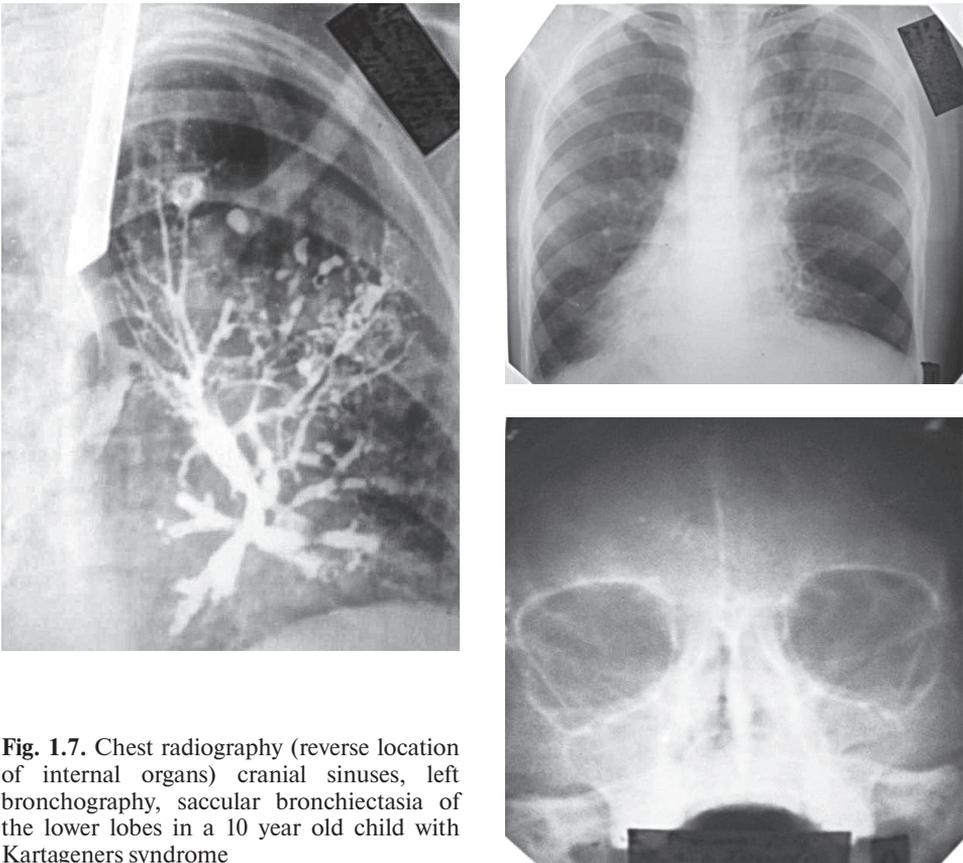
Chest radiography (reverse location of internal organs) cranial sinuses, left bronchography, saccular bronchiectasia of the lower lobes in a 10 year old child with Kartageners syndrome
